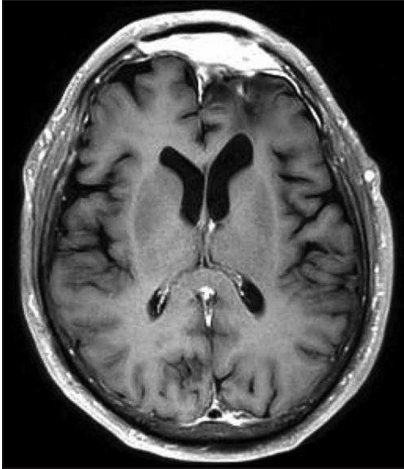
Postoperative surveillance MRI brain (T1 postcontrast) demonstrates no evidence of residual or recurrent disease.
